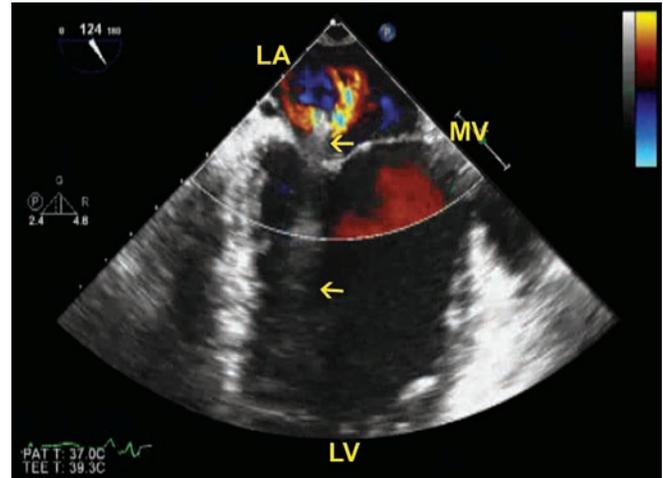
Transesophageal echocardiography. Upper and lower arrows point to the lead in LA and LV, respectively.
